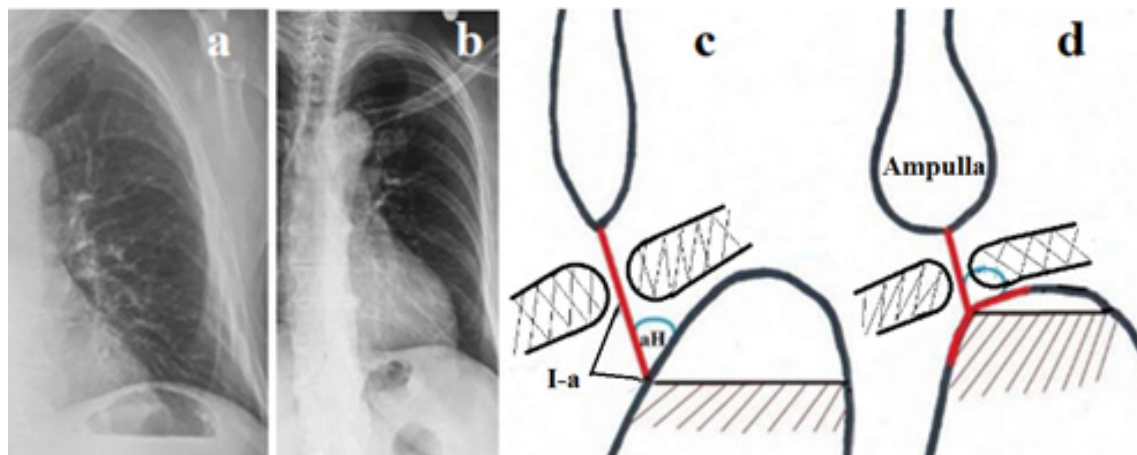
(a). Radiograph of the left dome of the diaphragm of a healthy person. (b). A patient with GERD. (c). Scheme of the EGJ with normal LES function (red line is LES length). The angle of His (aH) is acute. Large gas bubble in the stomach. (d). In GERD, the LES is shortened because the intra-abdominal part of the LES (I-a) is not functioning. This leads to an increase in the angle of His and a decrease in the gas bubble of the stomach due to belching during transient relaxation of the weakened part of the LES.
